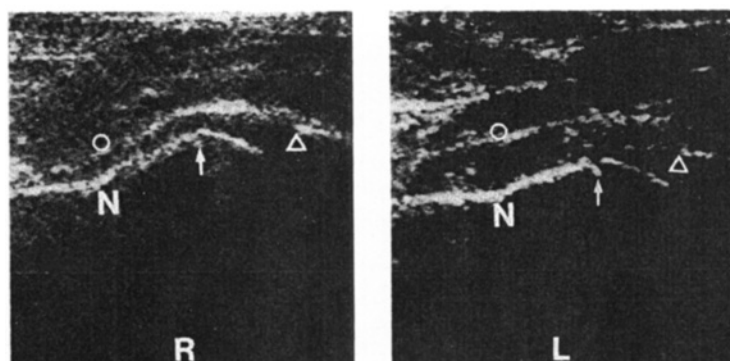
B. Anterior ultrasonograms one week postoperatively (labels as in Figure 1), depicting a considerable hip effusion but no physeal slip of the left hip.
